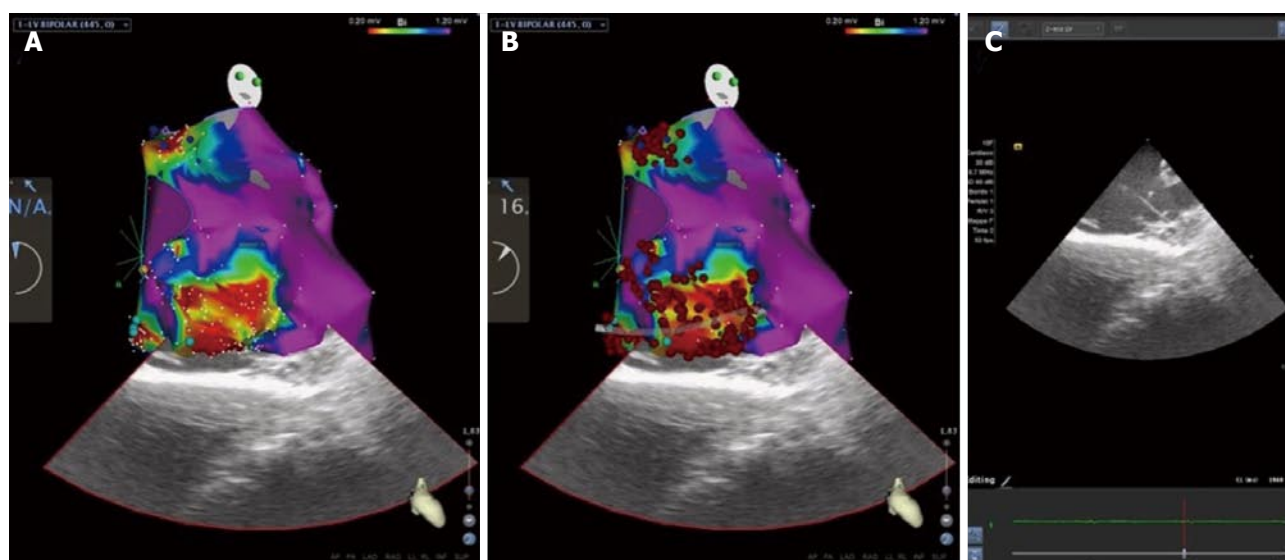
Modern approach of mapping and ablation for the treatment of electrical storm: High-density electroanatomical mapping of the left ventricle using CARTOSOUND contact-force technology (Biosense Webster, Diamond Bar, CA, United States). A: Two distinct peri-valvular scars, in the mitro-aortic continuity and below the mitral annulus, in the setting of idiopathic cardiomyopathy are visualized. Scars are characterized by dense scar (abnormal bipolar electrograms < 0.20 mV), surrounded by a border zone (0.20 - 1.20 mV) in which late potentials, are tagged (dark and light blue dots); B: Radiofrequency ablation lines are dragged for dechanneling and isolation of all proarrhythmic sites; C: Intracardiac echocardiography imaging is aiming at substrate characterization and correct positioning of the catheter during mapping and ablation.
